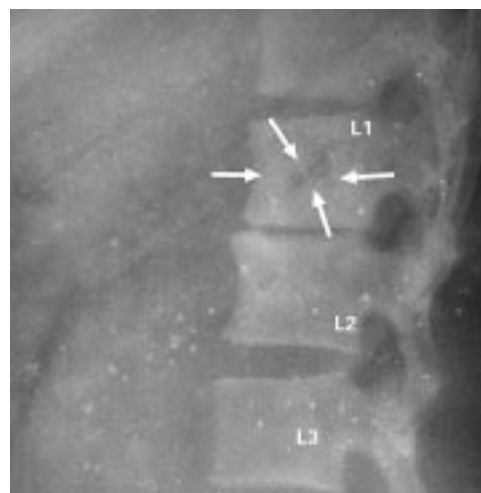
Radiograph of lumbar spine (lateral view) showing osteolytic area in the body of L1 vertebra (arrows). Note narrowing of the L1–L2 space.
